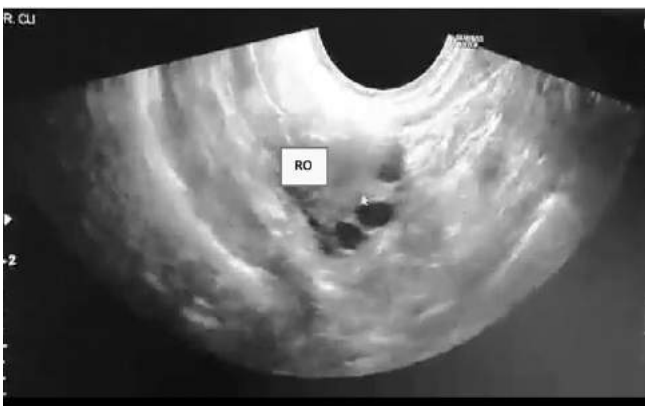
Transrectal sonogram showing the right ovary with follicles. RO-right ovary.
